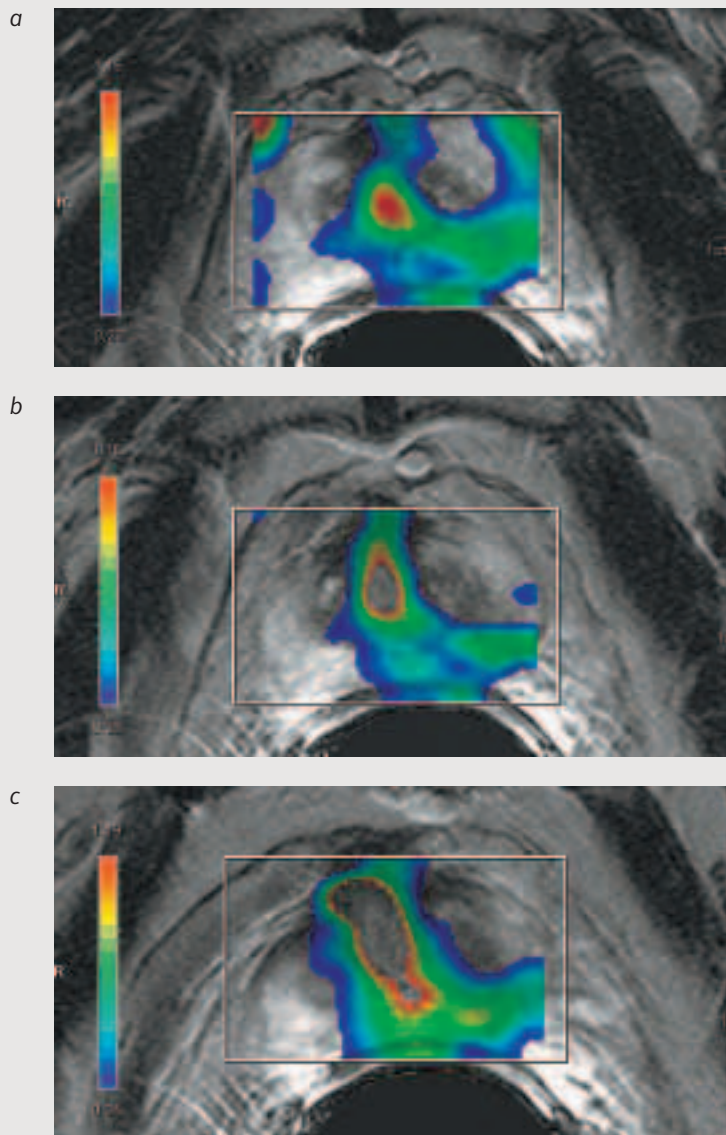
to c Three metabolite ratio images of the base of the prostate, overlaid on adjacent T2-weighted images. Deviating Choline over citrate ratios are detected in the center of the prostate, extending to the left peripheral zone towards the seminal vesicles.
